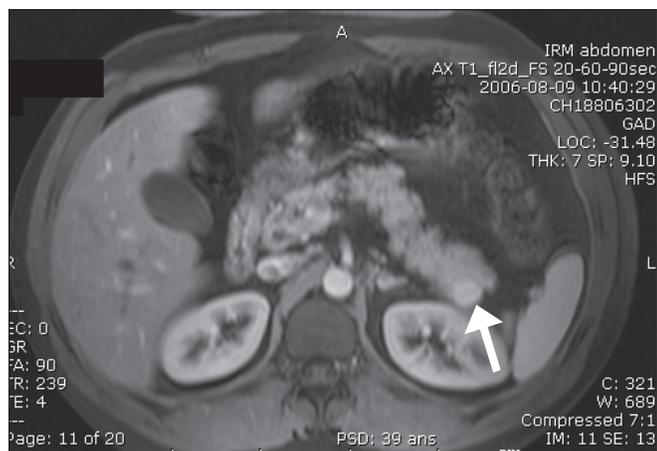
A T₁-enhanced magnetic resonance imaging scan taken after the administration of intravenous gadolinium contrast showing increased density of the lesion in the arterial phase (white arrow).
